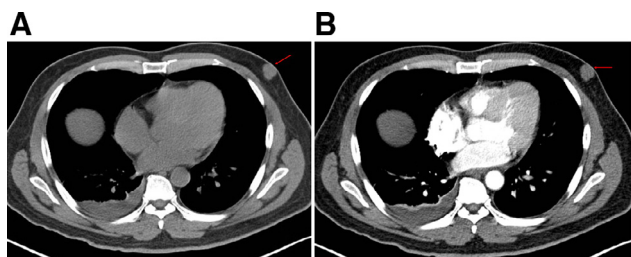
CT without (A) and with contrast (B) showing a lobulated mass located in the left breast without calcifications or skin retraction. Enhancement is seen after the contrast administration. There is also right pleural effusion with atelectasis.
